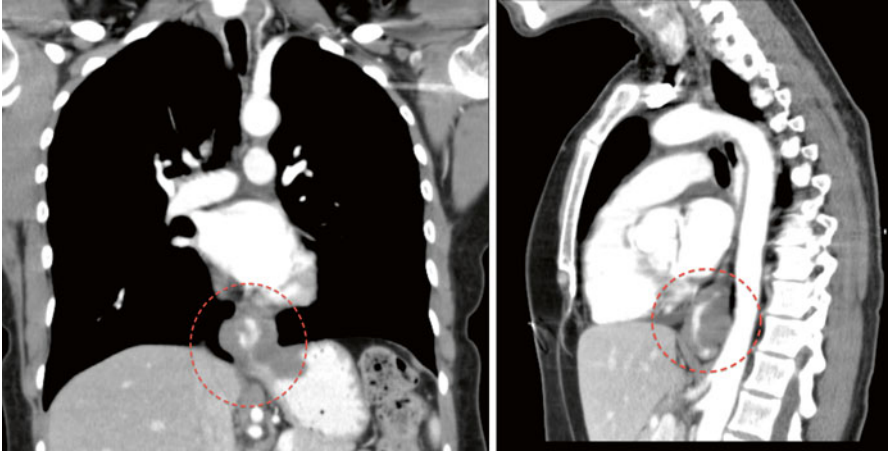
Chest/abdominal CT scan. Distal esophageal adenocarcinoma, coronal and lateral view (*red circles*)
